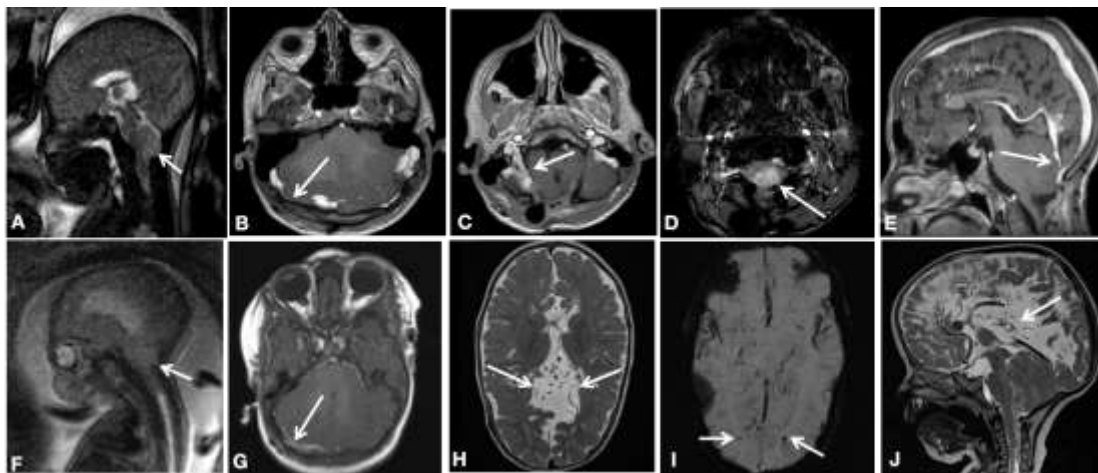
Postnatal MRI of two cases shows abnormal venous structure.
